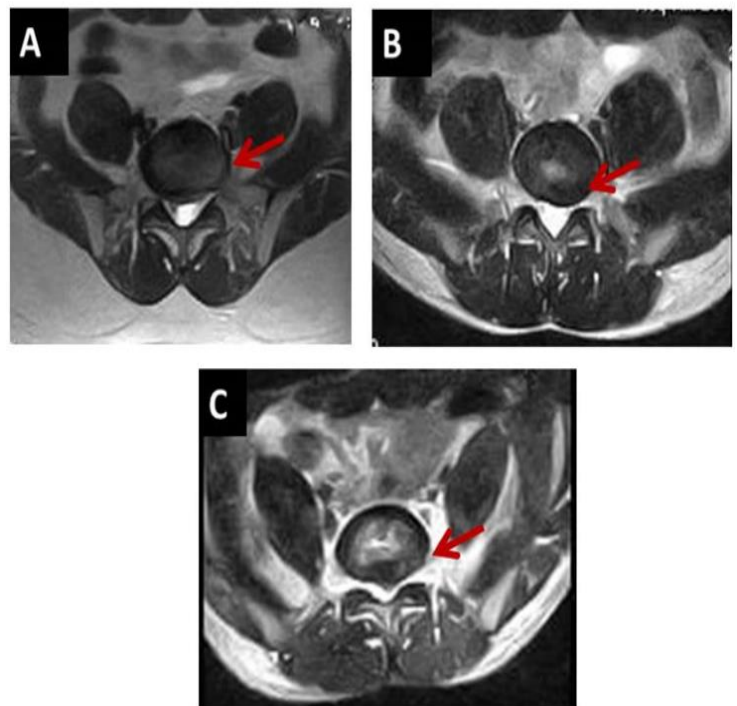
T2 Weighted images of MRI in transverse section showing A) Diffuse disc bulge B) Asymmetrical disc bulge C) Protrusion
